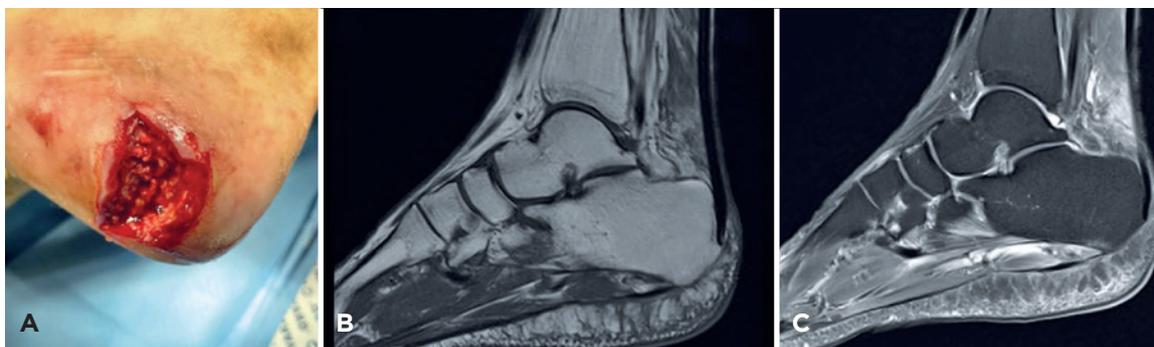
(A) Clinical photo of the plantar portion of the calcaneus after initial debridement. (B) Magnetic Nuclear Resonance Imaging (MRI) - Sag T1. (C) Magnetic resonance imaging - Sag T2. MRI images show mild edema and liquid slides in the adjacent fat pad but without extension to the deep bone plane or signs of osteomyelitis.
